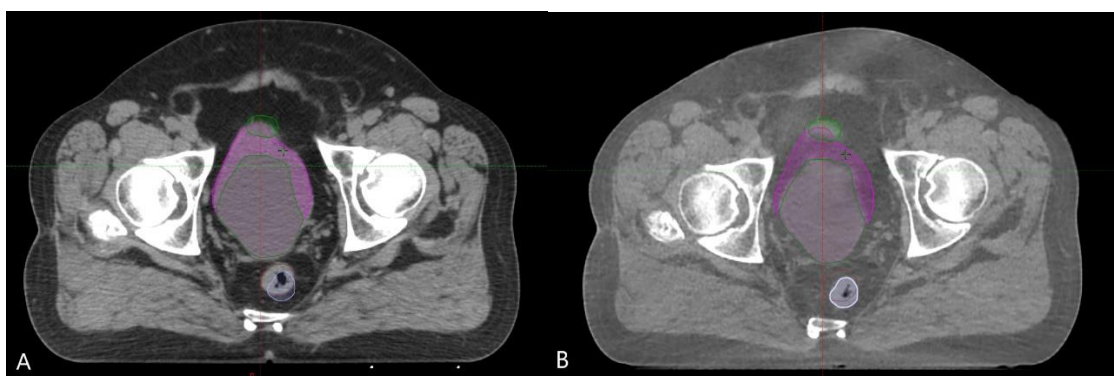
A – CT image with reference line of the rectum (purple colour), B – iCBCT image with rectum line (purple colour)
